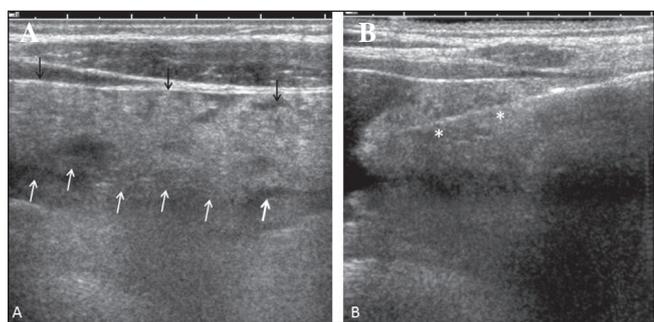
Right flank ultrasonogram. A. Properitoneal fat infiltration by an echogenic lobulated structure consistent with peritoneal infiltrative tuberculosis; it coincides with the most thickened area of peritoneum seen in the CT scan on the right side (Fig. 1B). B. US-guided biopsy: The needle (asterisks) and peritoneal fat infiltration may be seen.
